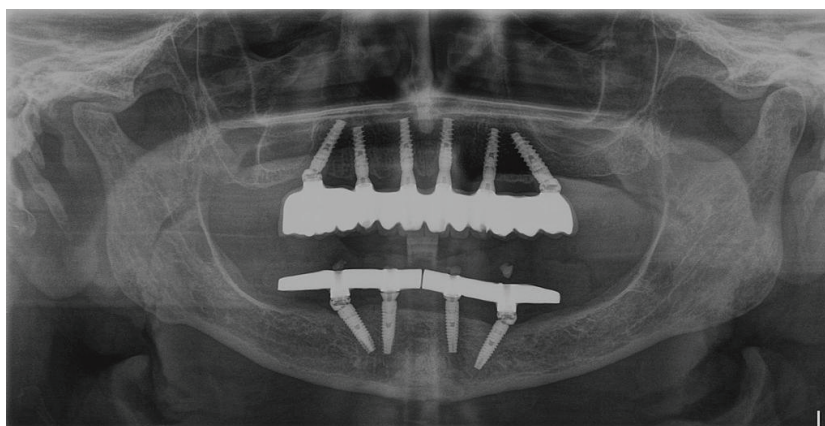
12-month follow-up radiograph
